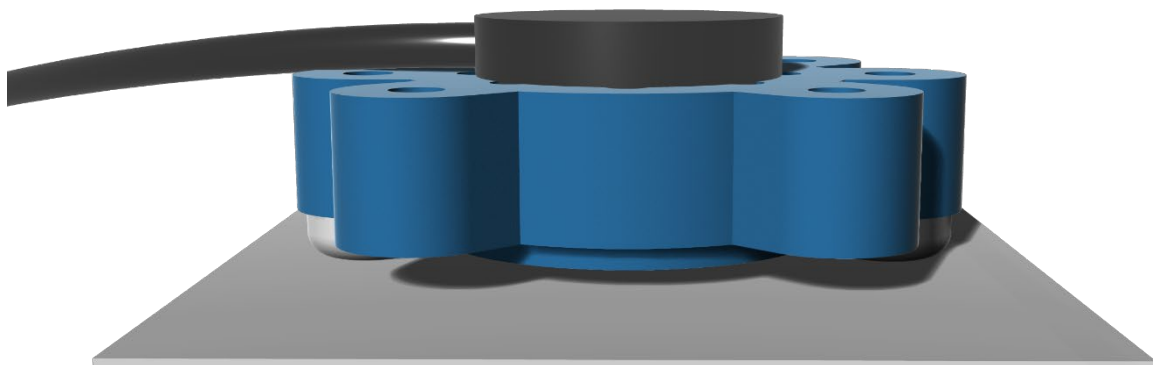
Render of transducer mount and skull analogue. The ultrasound transducer (black) sat in a 3D-printed housing (blue), which was mounted to a stereotaxic height control (not shown). For measurements with a skull analogue, the PTFE (white) was directly below the transducer mount, with a 4.8-mm gap between the transducer face and the PTFE. The PTFE was mounted to the same stereotaxic rig (not shown).
